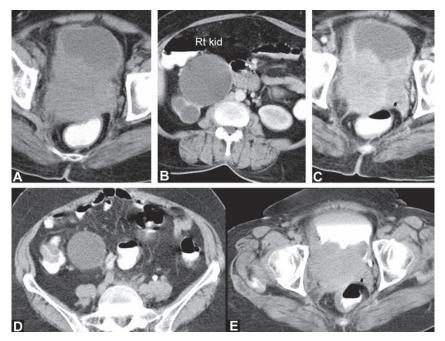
to D: CT pelvis shows collection in the uterine cavity lined on all sides by a thick irregular endometrial wall. Biopsy proved this to be a high grade endometrial carcinoma
